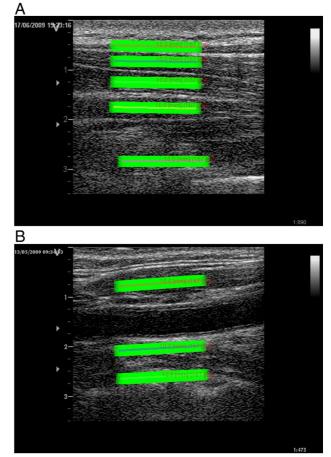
A*, Longitudinal ultrasound image of dorsal neck muscles with ROIs from superficial to the deep: trapezius, splenius, semispinalis capitis, semispinalis cervicis, and multifidus. B, Longitudinal ultrasound image of ventral neck muscles with ROIs from superficial to the deep: sternocleidomastoid, longus capitis, and longus colli. (Color version of figure is available online.)
